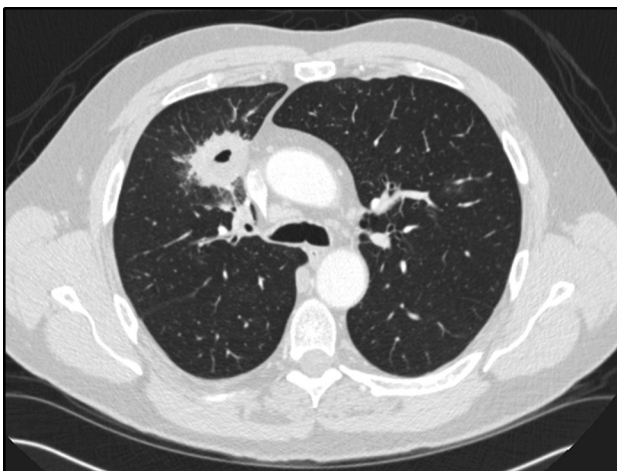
Chest computed tomography scan demonstrating a 4-cm cavitated lung mass in the right upper lobe abutting the mediastinum.
